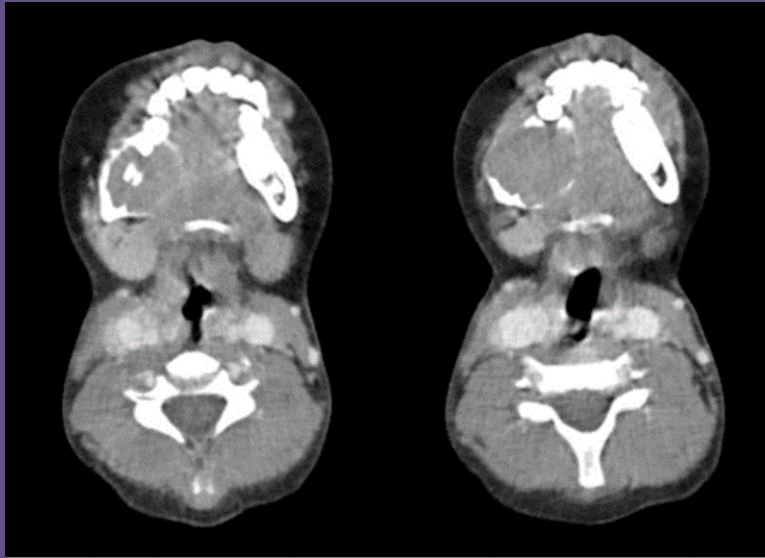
CT axial image showing expansile lytic lesion with thinned cortex and enhancing soft tissue component in the body of right mandible measuring 2.9 x 3.1 cm, the crown of an unerupted tooth is noted within
